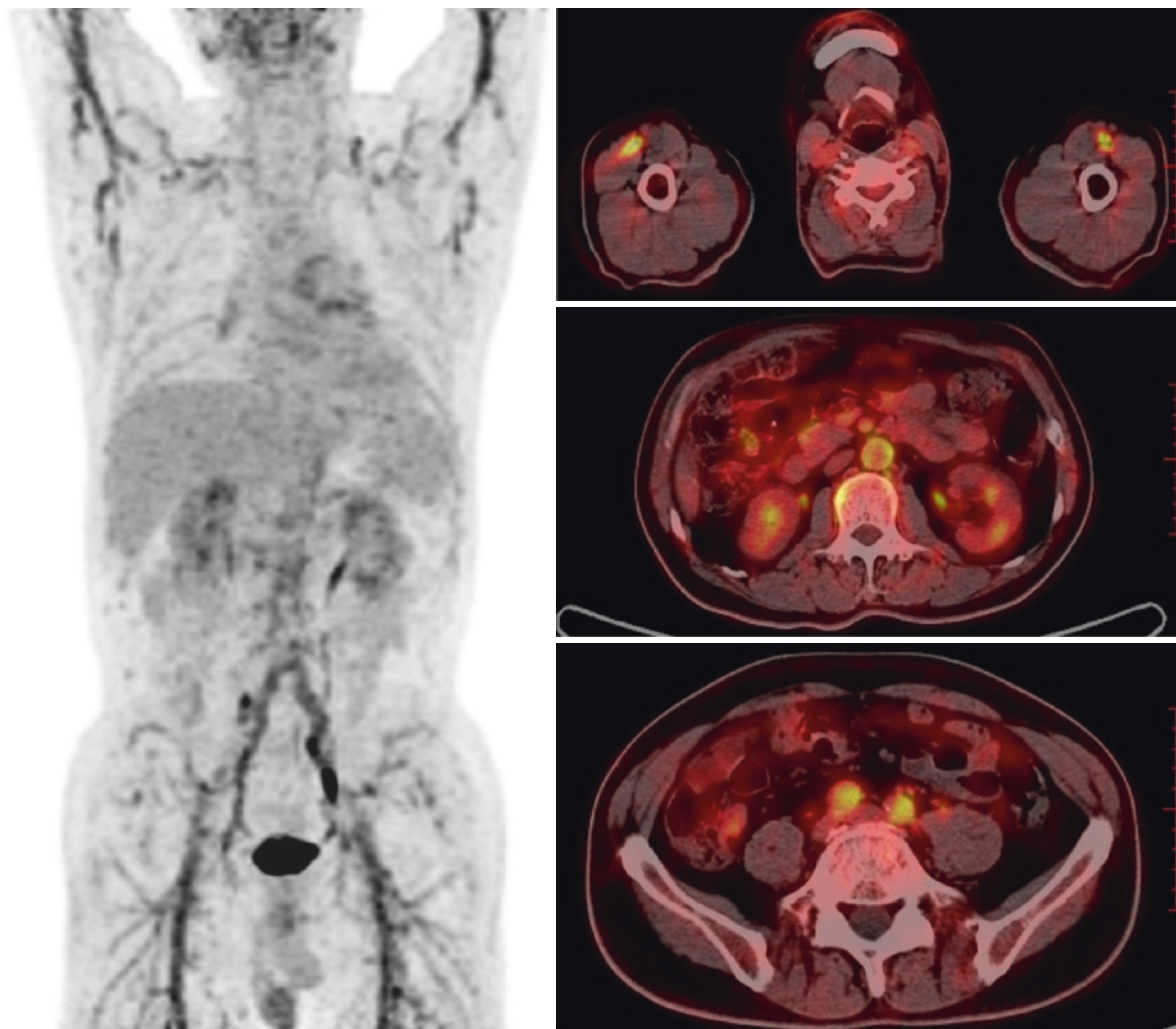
FDG PET/CT images
